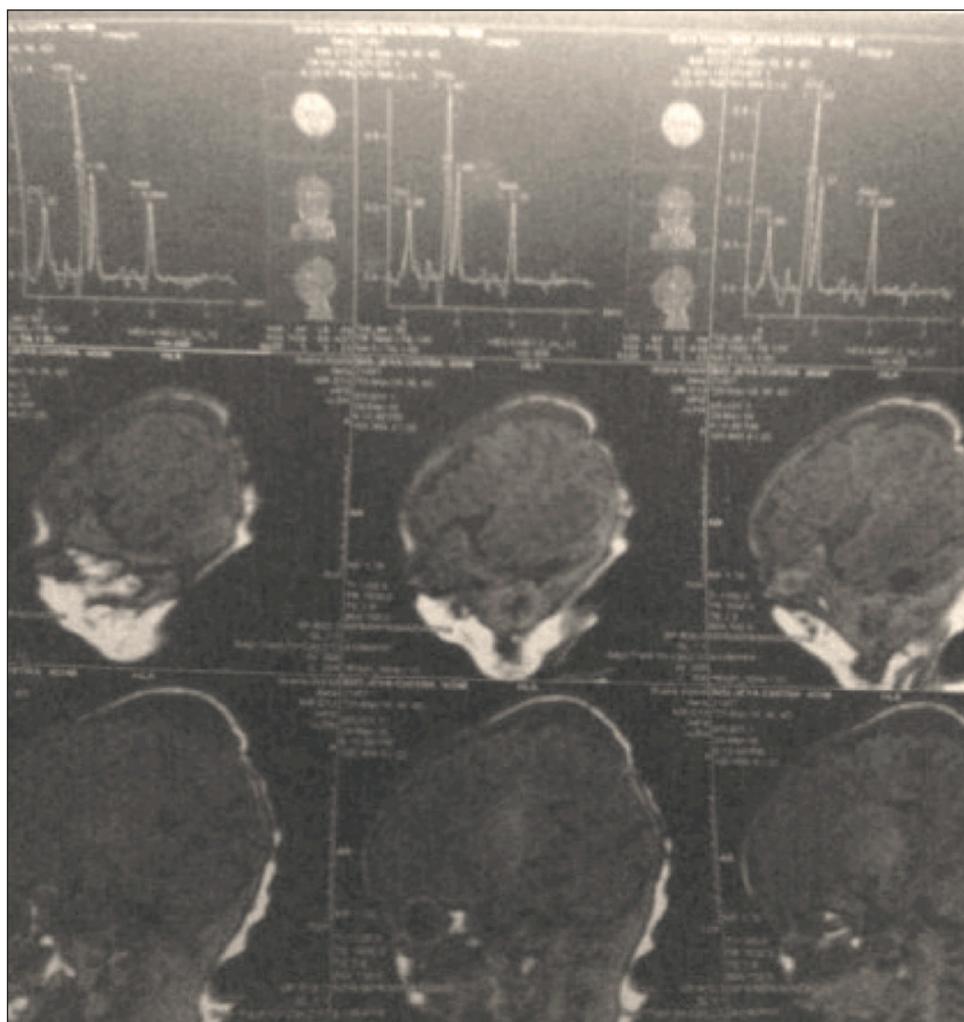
Magnetic resonance imaging revealing T2 intense images from the bilateral frontoparietal deep white matter, corpus callosum, internal capsule, and posterior thalamus suggestive of chikungunya encephalitis.
